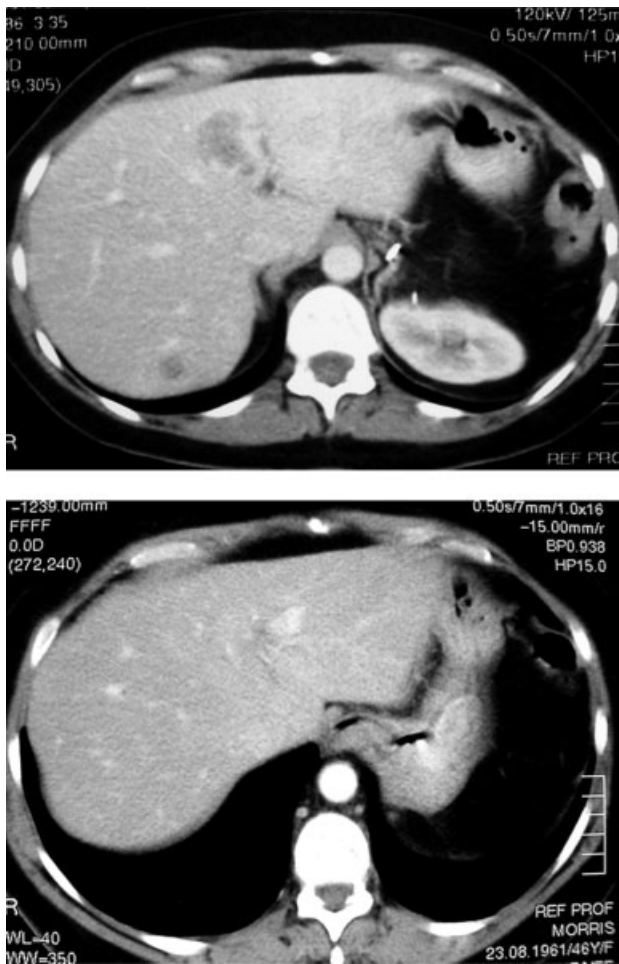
Computed tomography scans before (*Top*) and 36 months after (*Bottom*) ^{90}Y radioembolization in a patient who had a complete response in the liver.
